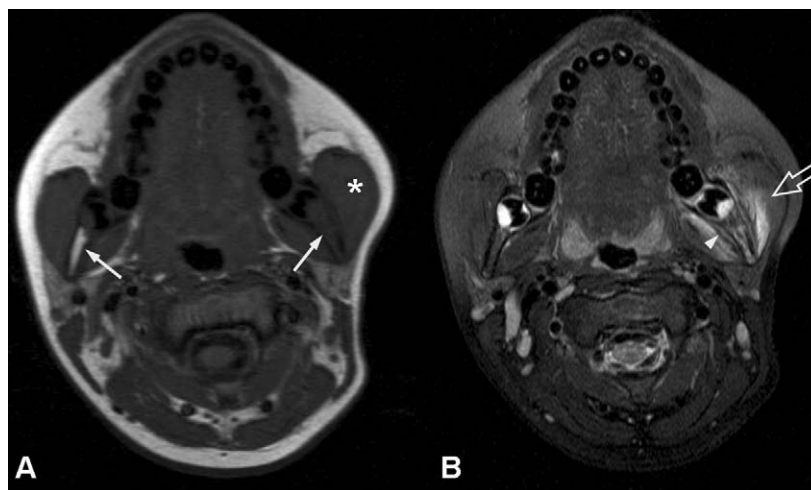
Axial T1 (A) and axial T2 fs (B) MRI images showing osteomyelitis of the mandible on the left side. Marked edema and replacement of fatty bone marrow are visible as signal loss on the T1 image (A: right arrow), and a signal increase on the T2 fs image compared to the normal right side of the mandible (A: left arrow). The periosteum of mandibular angle is thickened (B: arrowhead). The masseter muscle on the diseased side (A: asterisk) is enlarged, and with inflammatory edema in the masticator muscles visible as a diffuse signal gain in a T2 fs image centered on the mandible (B: open arrow).
